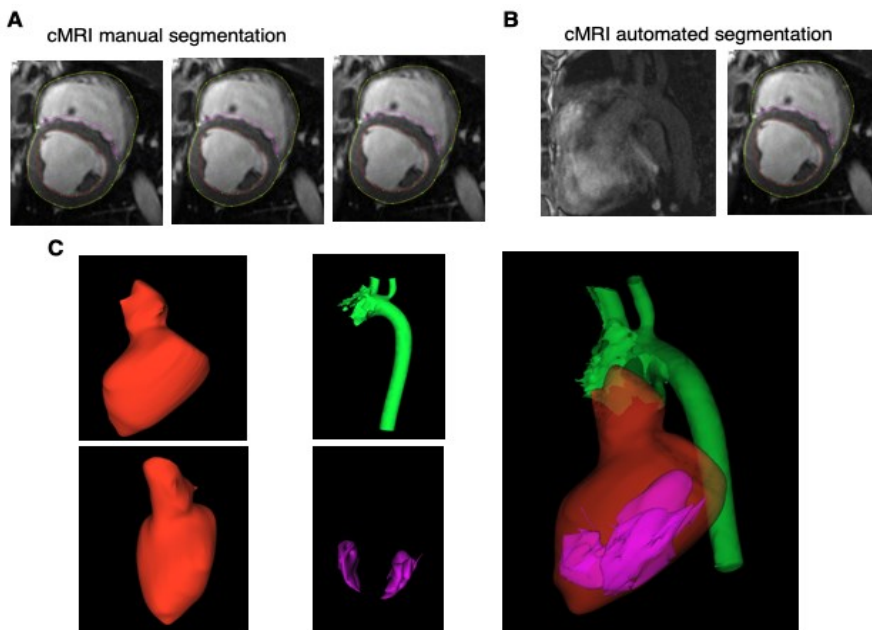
Cardiac magnetic resonance image segmentation and 3D model.
